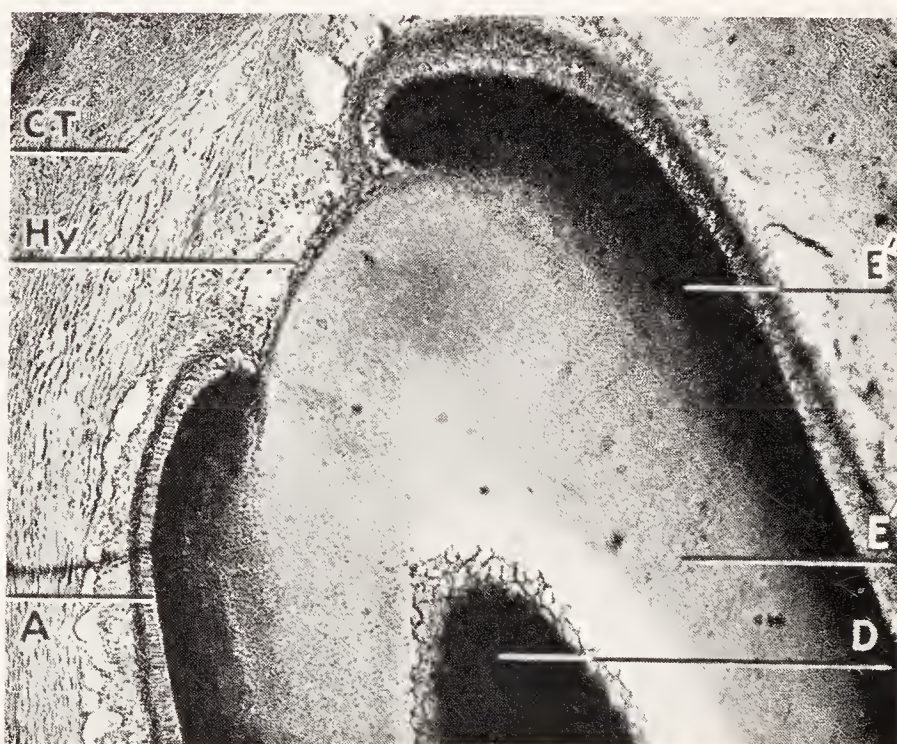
Enamel hypoplasia near the incisal edge of a permanent tooth germ of a rachitic child. *D*, dentin; *E'*, inner zone of enamel; *E''*, outer zone of enamel; *A*, ameloblasts; *Hy*, enamel hypoplasia; *CT*, connective tissue surrounding the germ. (Courtesy of J. R. Blayney.)
